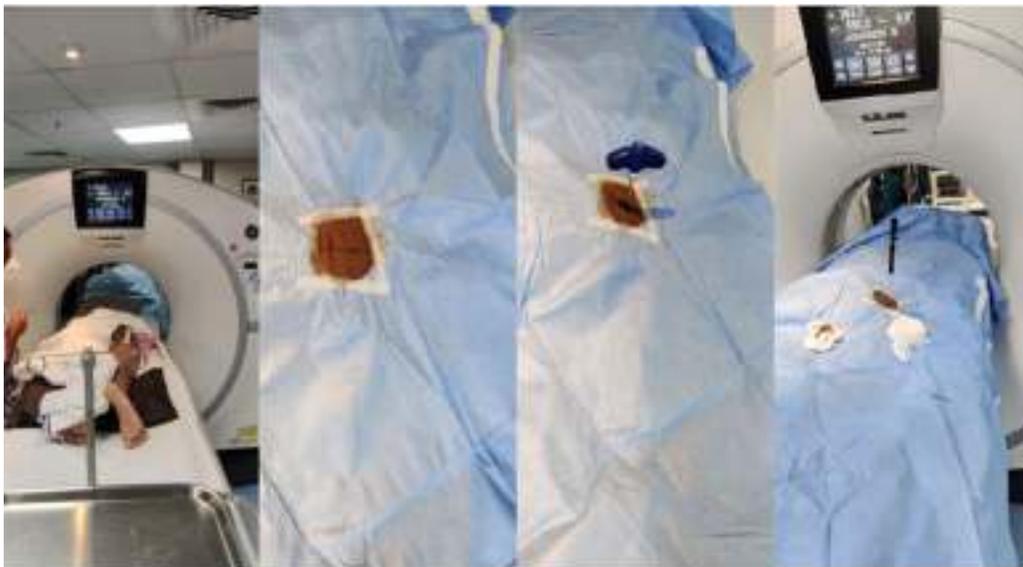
Positioning on computed tomography table with electrode
